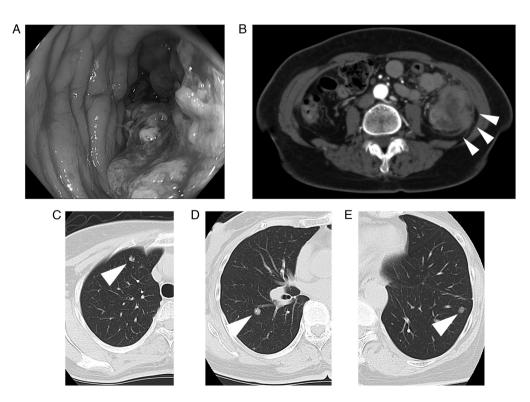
Clinical images of case 2. (A) Preoperative colonoscopy revealed an ulcerated tumor in the descending colon of case 2. (B) Computed tomography demonstrated the contrast-enhanced wall thickening of the descending colon (white arrowheads). Computed tomography revealed two metastases, (C) 8 and (D) 9 mm in diameter, in the right lung (white arrowheads). Partial right upper and lower lobectomies were performed after the resection of the primary lesion. (E) At 2 months after the right pneumonectomy, a new metastatic lesion appeared in the left lung (8 mm in long diameter; white arrowhead). A partial left lung resection was then performed.
